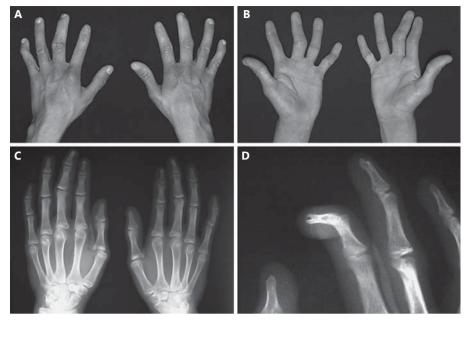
A–D The hands of the patient showing mild camptodactyly (mainly of 5th finger), short hands, bilateral hypoplasia of the distal phalanges of fingers 2 and 3, with agenesis/hypoplasia of the nails (A, B). Xrays of the hands show gross and misshapen proximal phalanges of fingers 2 and 3, radial clinodactyly of finger 2, hypoplastic distal phalanges of fingers 2 and 3, abnormal 'bird-like beak' modeling of the right distal phalanx of finger 2 as well as a small bony fragment distal to the phalanx of finger 3, and a dislocation of the metacarpal phalangeal joints of both thumbs (C, D).
